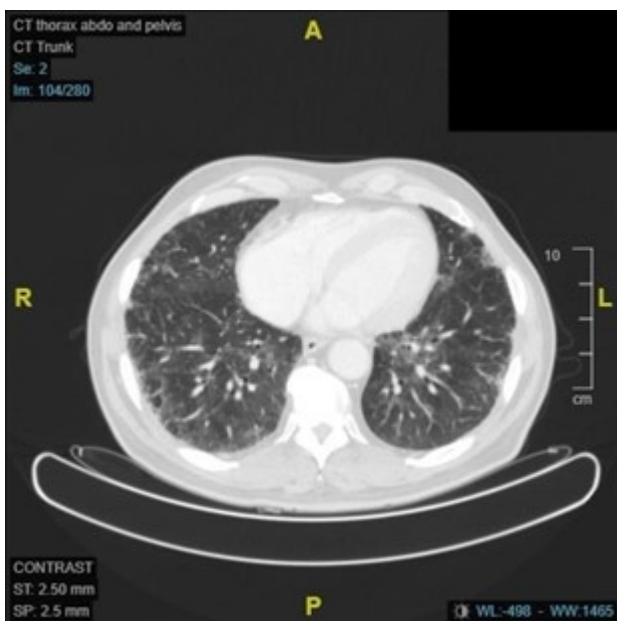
Re-staging CT Thorax after cycle 8
